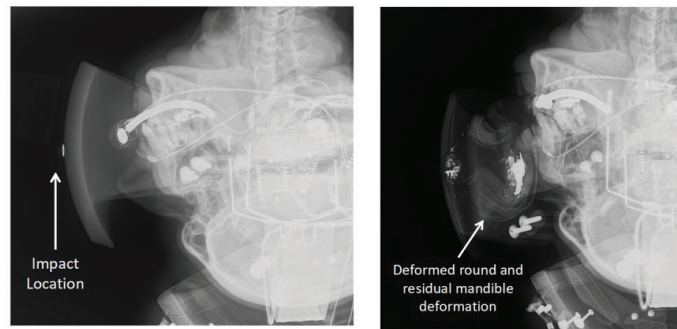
Lateral X-ray image of BMP and PMHS before impact (left) and image of BMP and PMHS directly after impact (right) for mid-sagittal maxilla impact (BMP_02)
